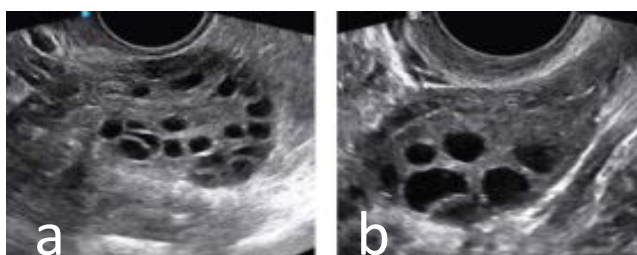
Sonographic images of the ovary in transvaginal ultrasound scan: a. Polycystic ovarian syndrome; b. Normal ovary (Lee and Rausch, 2012).
